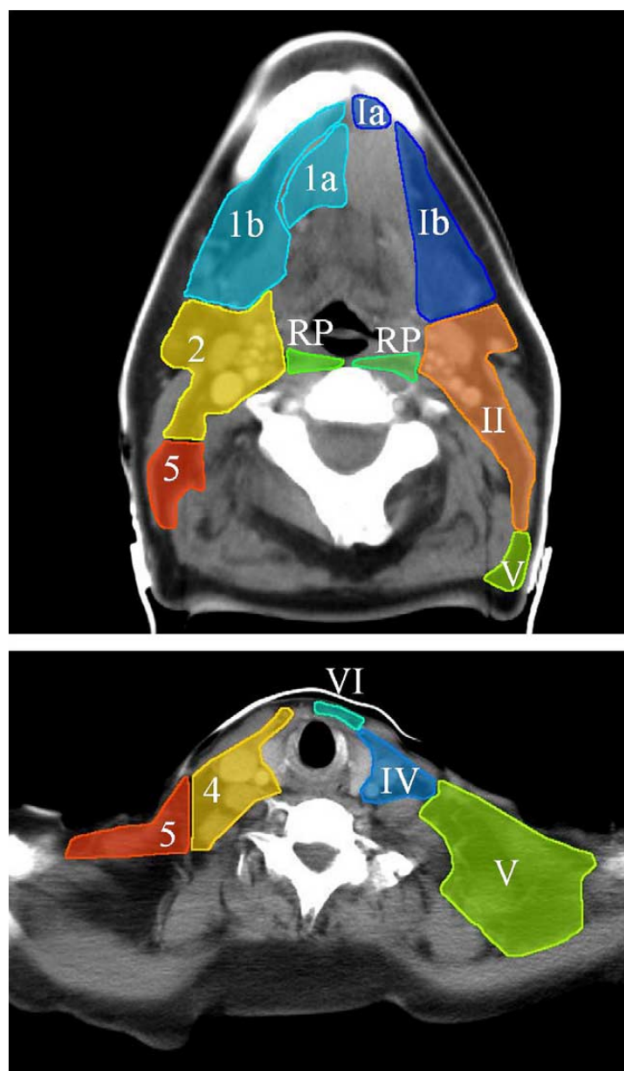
Comparison between the simplified Rotterdam (left side of the neck, Arabic figures) and the Brussels (right side of the neck, roman figures) guidelines for the delineation of the neck node levels. On the top, CT slice at the level of the basilar edge of the mandible; levels Ia, Ib, II and V, and retropharyngeal nodes (RP) are displayed. On the bottom, CT slice at the level of the cricoid cartilage; levels IV, V and VI are displayed.
